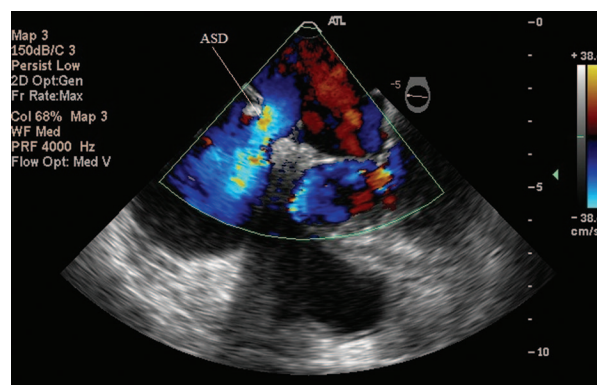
Color flow Doppler demonstrated flows between the atria. ASD = atrial septal defect.
